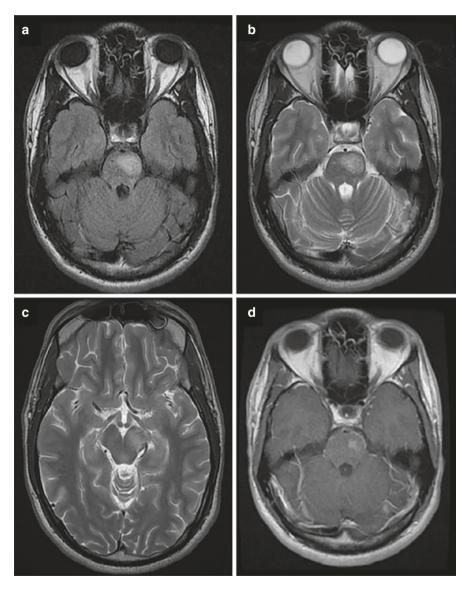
Brainstem involvement in a patient with Behçet disease. (a, b) Axial FLAIR and T2-weighted images showing left pons involvement with surrounding edema. (c) Axial T2-weighted image showing spread of the disease to the left midbrain. (d) Central nodular enhancement of the lesion is seen on post-contrast axial T1-weighted images
